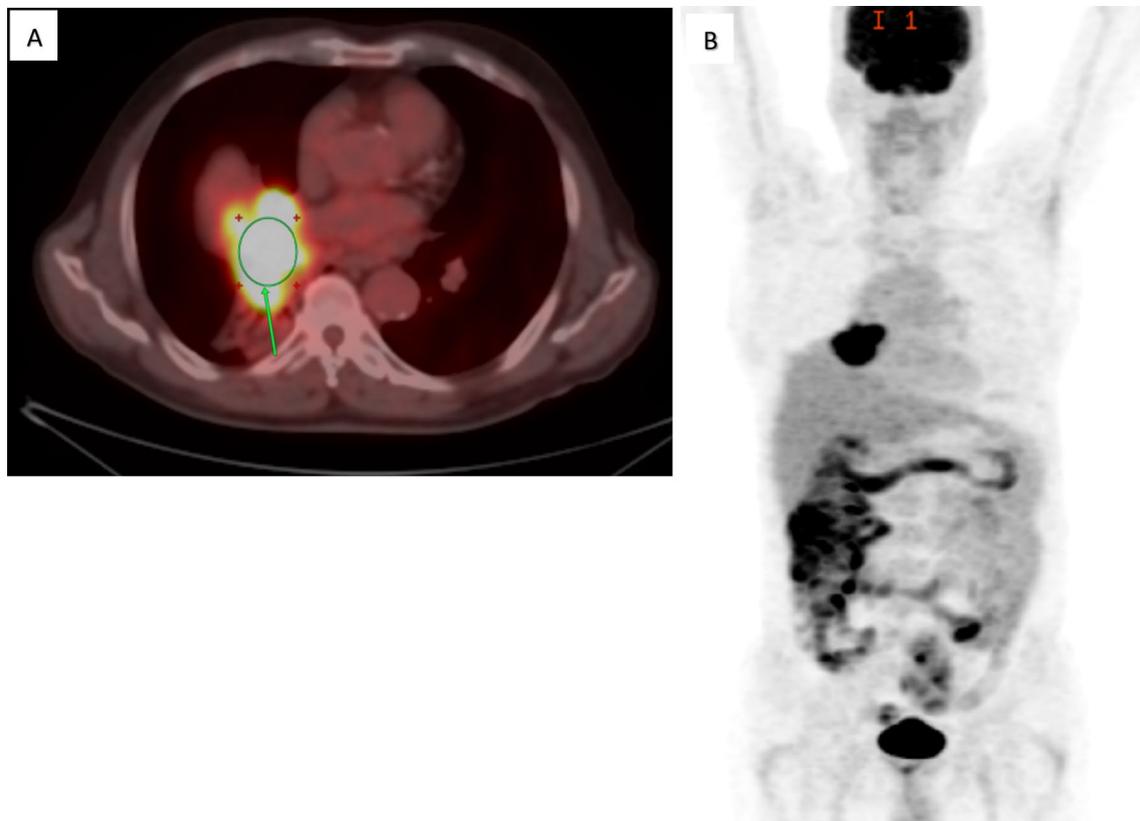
66-year-old gentleman with recent bronchoscopy showing a right bronchial mass lesion. (Fig. 4). A–B (FDG) PET/CT. A Metabolically active large right lower lobe central peribronchial soft tissue mass lesion (arrow) is seen cuffing the left lower lobe bronchus with consequent narrowing of its lumen, the lesion measures about 74 × 44 mm and showing max.SUV ~ 17. B Full-body coronal MIP PET showing the primary lung mass with no other distant metastasis. The tissue sampling proved to be undifferentiated large cell carcinoma
